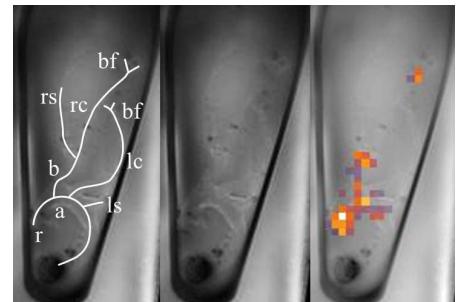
Ex vivo images of excised aorta: centerlines of the arteries (left), ^1H MRI (middle), ^{19}F MCSS-RARE overlay (right). a) aorta, b) brachiocephalic artery, lc/rc) left/right carotid, bf) carotid bifurcation, ls/rs) left/right subclavian artery, r) aortic root.
